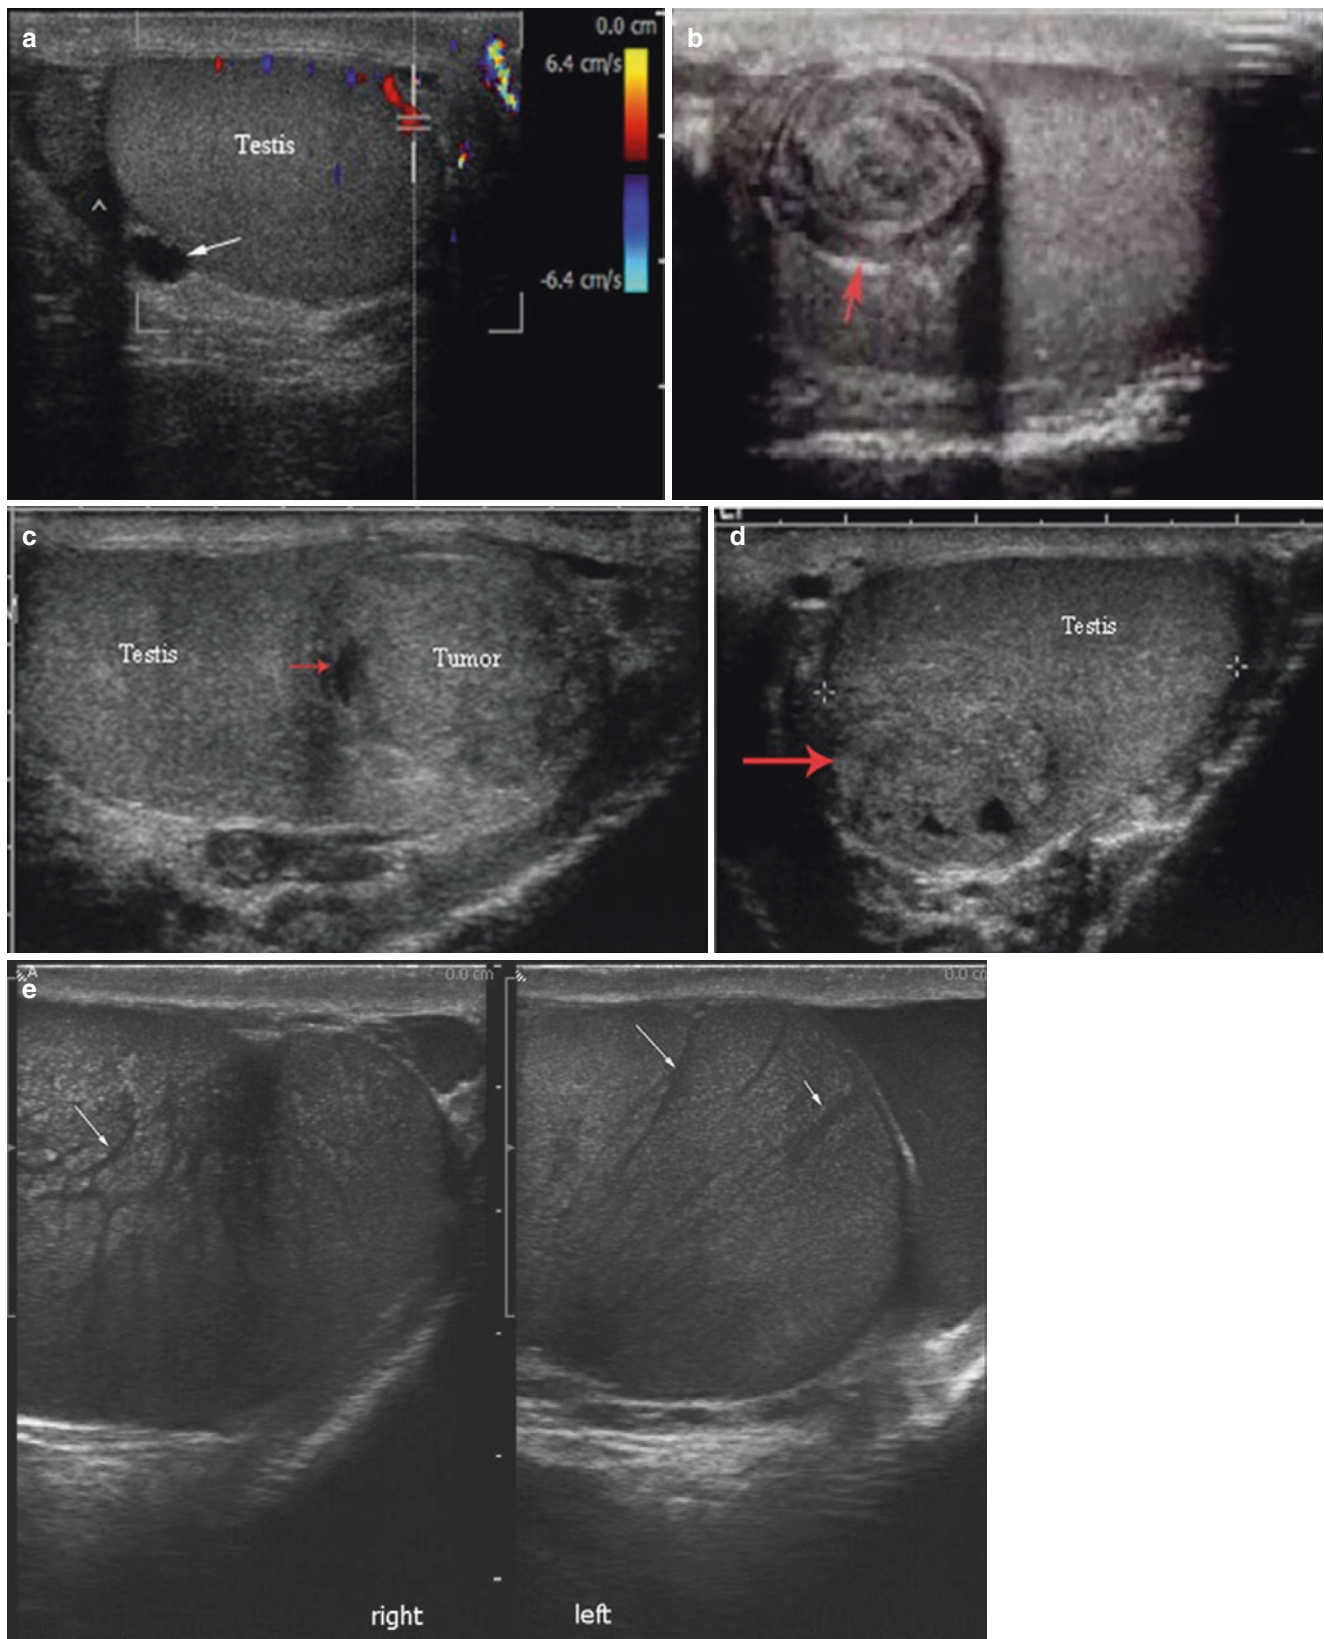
(a) Many non-neoplastic and neoplastic testicular masses may be visualized with ultrasound. Simple testicular cysts are anechoic, and well-circumscribed. Tunica albuginea cysts are often found in the upper or lateral margins of the testes, and may be palpable. (b) An epidermoid cyst classically has an “onion ring” appearance due to alternating layers of hypoechogenicity and hyperechogenicity; and does not demonstrate flow when color Doppler is used. (c) Germ cell tumors account for approximately 95% of lesions, with the remainder being mostly sex cord stromal
